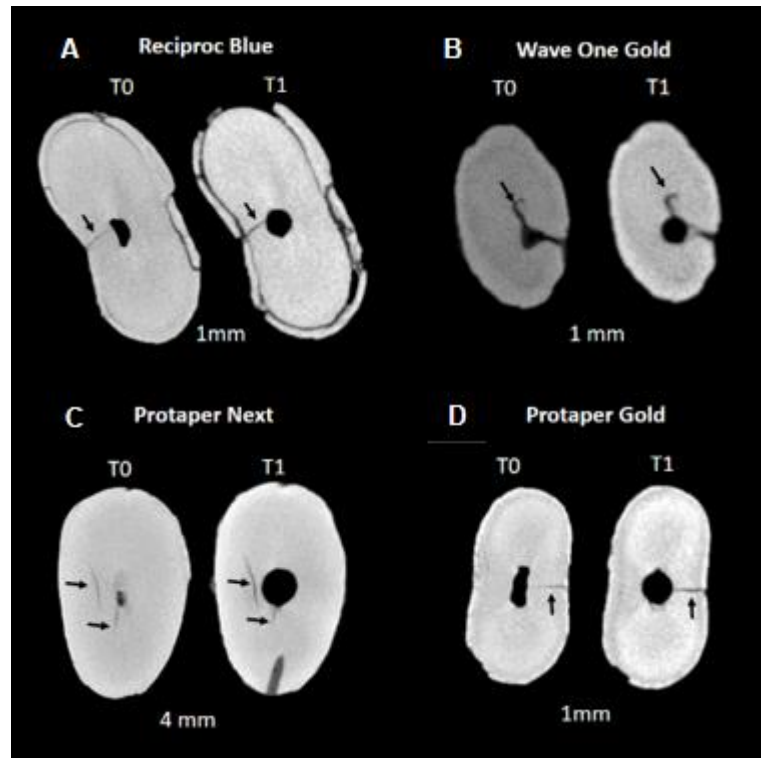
Representative cross-sectional microcomputed tomography images obtained with Reciproc Blue (A), Wave one Gold (B), Protaper Next (C) and Protaper Gold (D) systems root cracks (indicated by arrows), which continued or increased after (T1) instrumentation.
